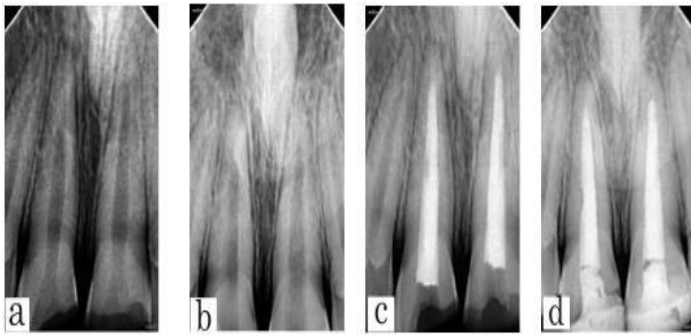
2. showing radiograph of Preoperative (a), Biodentine apical plug (b), thermoplastic obturation (c), 8 months follow up (d).
